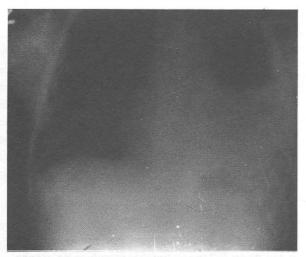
Initial chest roentgenogram at the time of diagnosis shows pleural effusion and lung compression between 10 %-30 % of left hemithrorax. B. CT scan of patient at the time of diagnosis. Note a 30 % loss of lung expansion by the empyema.
